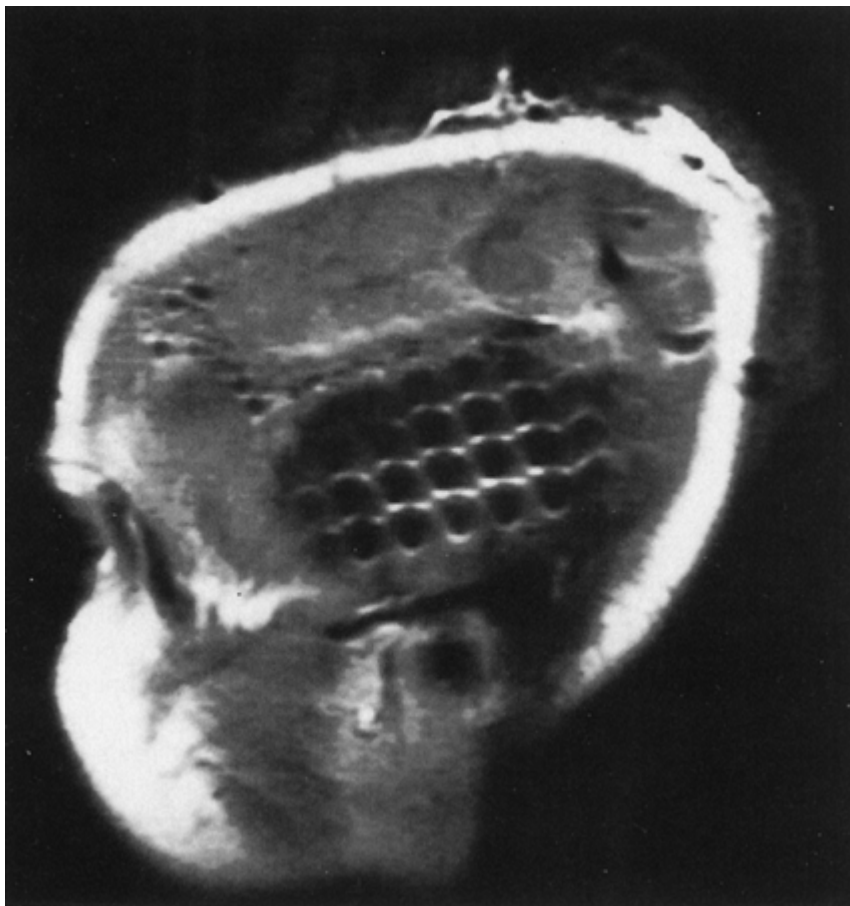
Sagittal magnetic resonance imaging (MRI) view of subdural grid placed to record from temporal neocortex.
